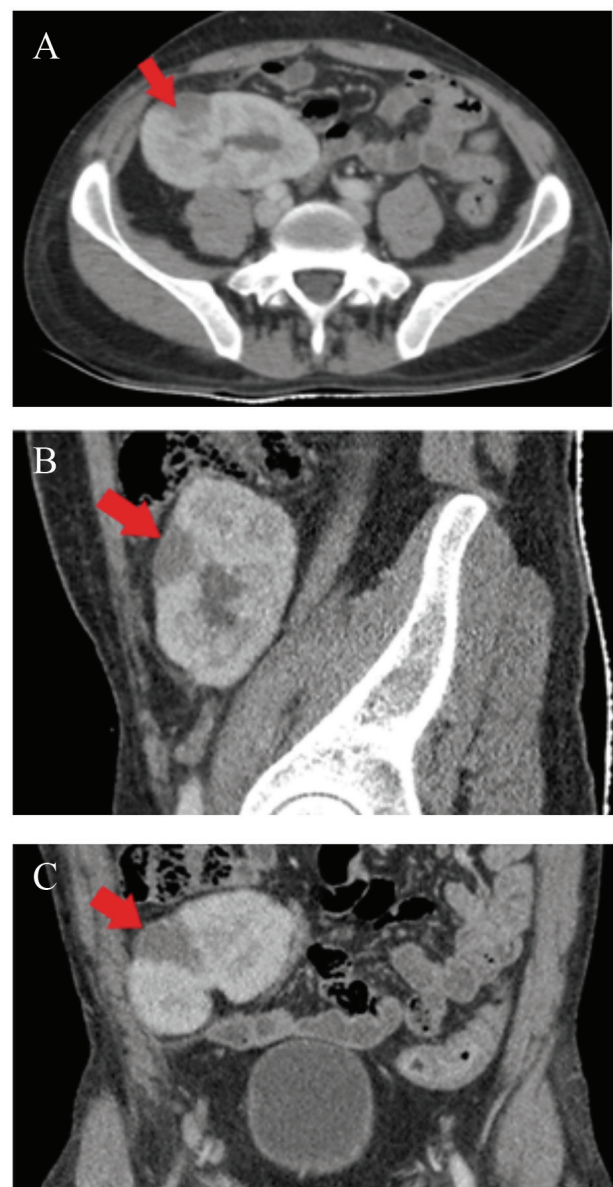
Contrast-enhanced computed tomography images reveal a sickle-shaped hypodense area at the renal anteroposterior cortex (red arrows). A: Axial plane, B: Sagittal plane, C: Coronal plane.
